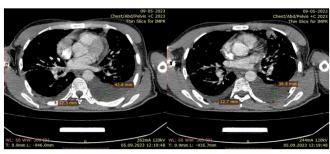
Chest CT scan (September 2023).
